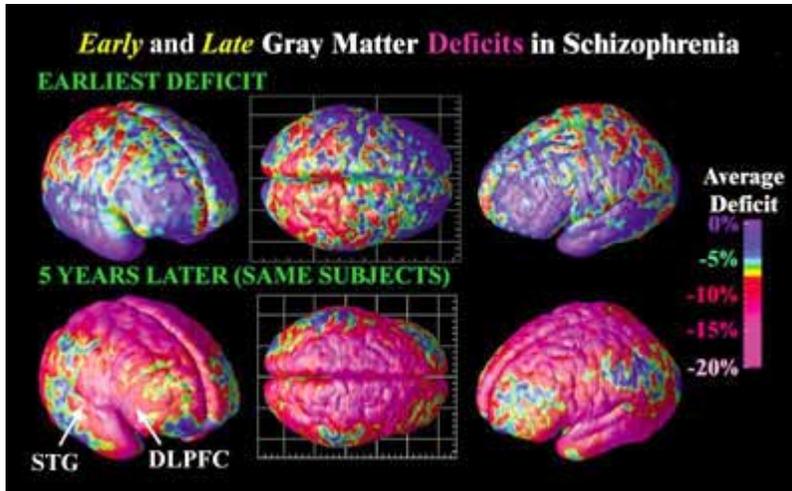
Dynamic Brain Maps: Mapping Brain Changes in Schizophrenia.* Derived from high-resolution magnetic resonance images (MRI scans), the above images were created after repeatedly scanning 12 schizophrenia subjects over five years, and comparing them with matched 12 healthy controls, scanned at the same ages and intervals. Severe loss of gray matter is indicated by red and pink colors, while stable regions are in blue. STG denotes the superior temporal gyrus, and DLPFC denotes the dorsolateral prefrontal cortex. Video sequences showing these dynamic changes can be viewed on the Internet at: <http://www.loni.ucla.edu/~thompson/MOVIES/SZ/sz.html> (Reprinted with permission from Thompson PM et al., *Proceedings of the National Academy of Sciences of the USA*, 98[20]:11650-11655<sup>10</sup>).
